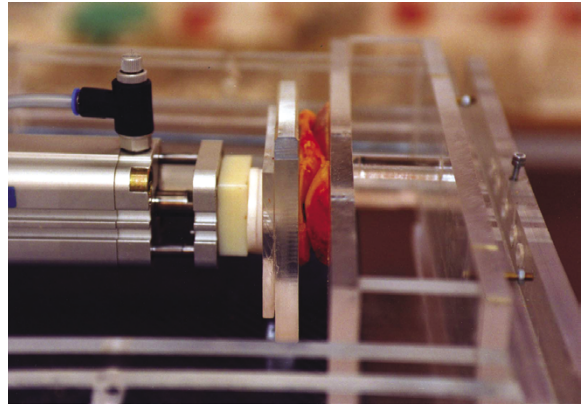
The experimental set-up. Exposure on the high resolution mammography x-ray film with the bone pieces under continuously pressure of the pneumatic piston with 40 kPa.
